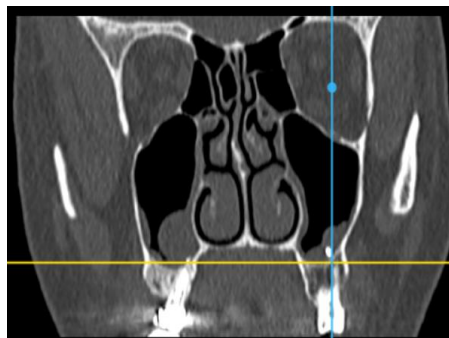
CT scan of the the right maxillary sinus demonstrating soft-tissue opacities consistent with polyp, CT scan of the left maxillary sinus demonstrating hyperdense filler materia and partial sinus opacification, consistent with secondary maxillary sinusitis. (CT Image provided by Dr. A. Gharibyan)
